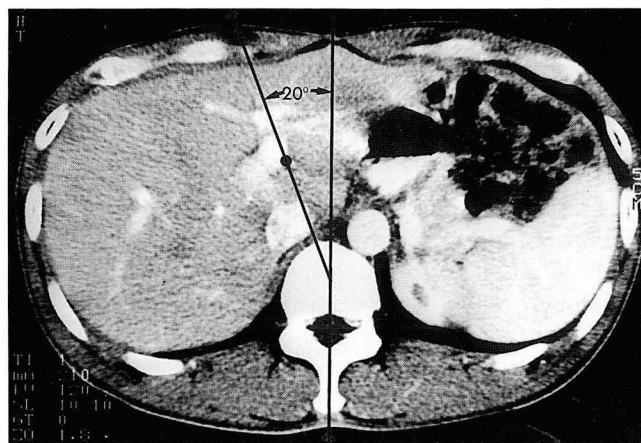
LPVA is determined by a line drawn through the center of the vertebral body to the umbilical point of the left portal vein and a vertical line drawn through the center of the rectus abdominis muscle to the spinous process of the vertebra. The angle measures 20° on this CT scan of a normal healthy subject. ●; umbilical point
